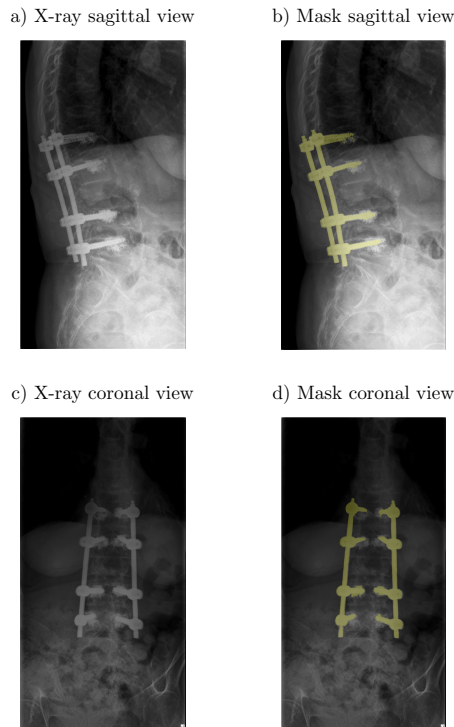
Segmentation of implants in X-ray images. a) and c) sagittal and coronal view of the spinal implant. Using a seeded region based segmentation strategy the implant position and geometry is obtained. This is overlaid onto the X-ray images in b) and d).
